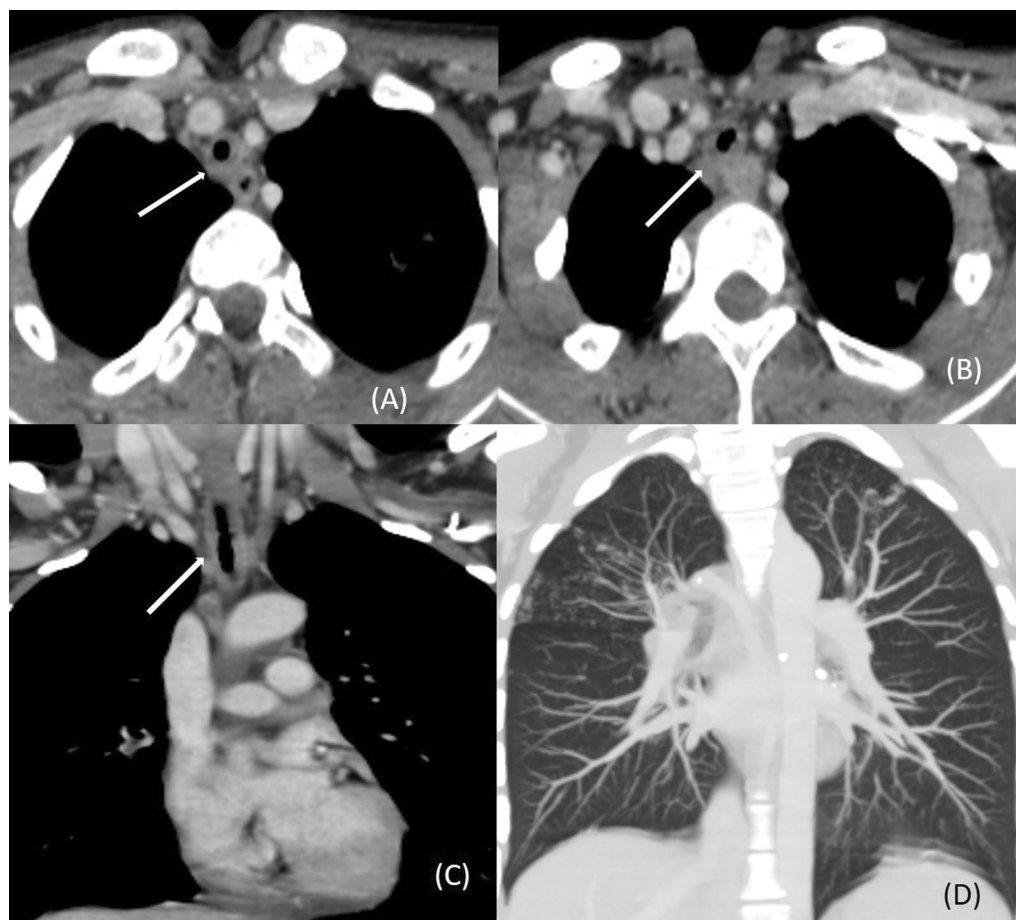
Tubercular tracheitis. CT images of a 23-year-old female show circumferential wall thickening of distal trachea (white arrow in A–C) and lung window shows tree-in-bud nodules in the right upper lobe (D)
